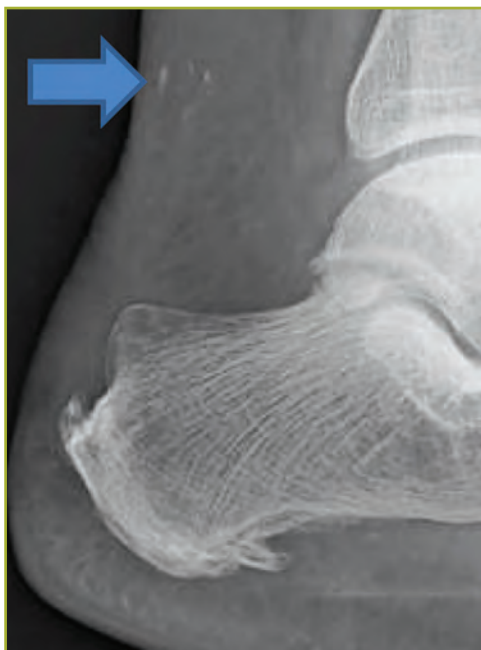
Radiograph showing faint radiodense specks (arrow; the “Pleiades sign”), seen in four of the eight patients with sleeve avulsion.
